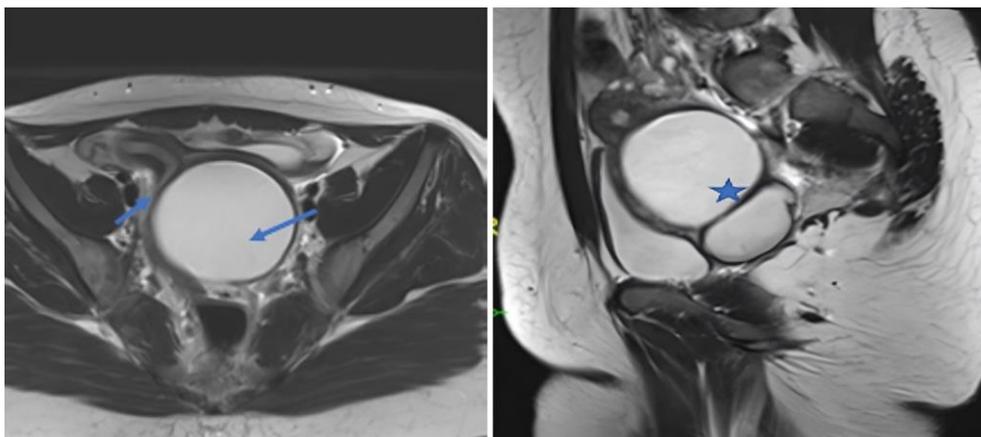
Pelvic MRI T2 sequence showing two cervixes (arrow) & a left side unilateral septated lobulated hematocolpos (star) (reprinted with permission of the patient)
